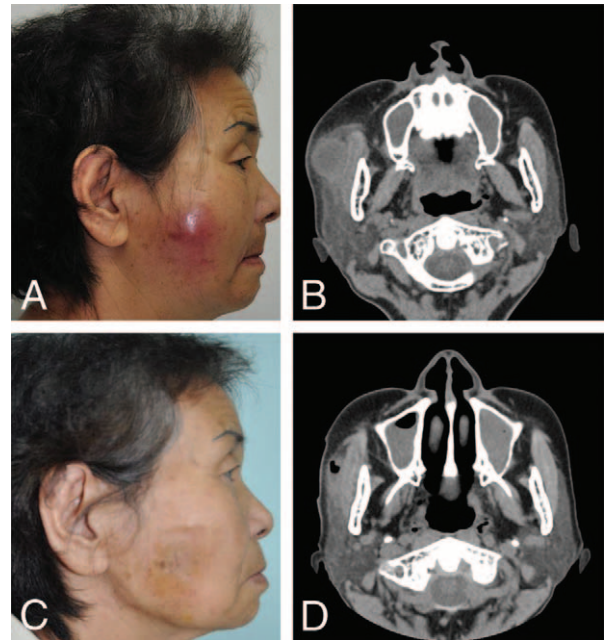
A, An 87-year-old woman suffering from mild swelling and induration of the left cheek region was observed preoperatively. B, Preoperative enhanced axial computed tomography scan shows a well-defined, ovoid, soft tissue cystic lesion (2 × 2 × 1.5 cm). C, Normalization of the cheek skin after 4 weeks. D, Postoperative enhanced axial computed tomography scan reveals a well-drained accessory parotid gland abscess.
